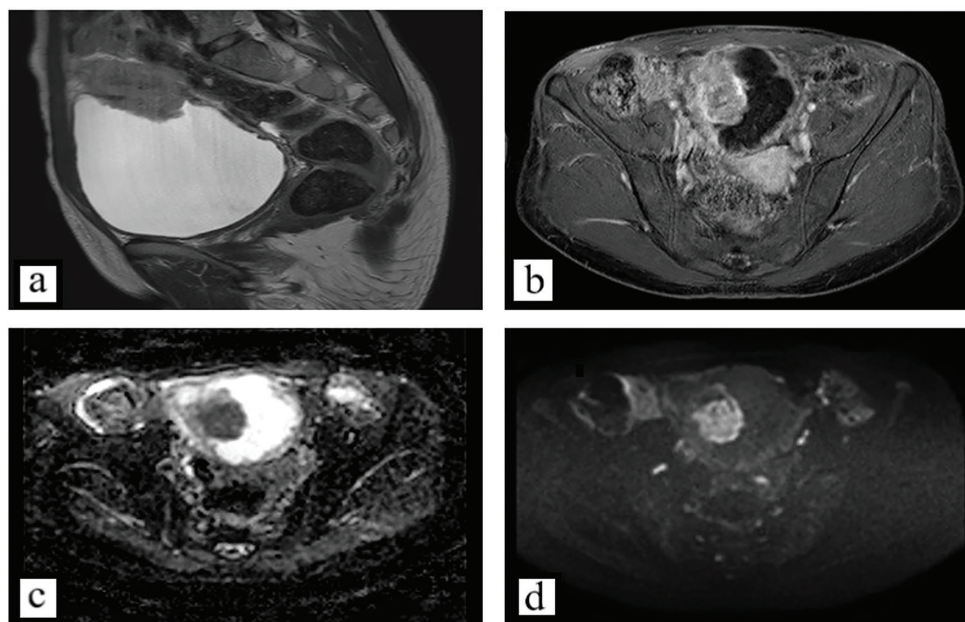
A 34-year-old woman presented with dysuria and recurrent urinary tract infections. Initial ultrasonography demonstrated a lesion in the bladder area. Subsequent magnetic resonance imaging (MRI) revealed a midline suprav vesical solid mass along the course of the urachal ligament and contiguous with the bladder dome, radiologically consistent with originating from urachal remnants. On MRI, the lesion appeared iso- to hypointense on T2-weighted sequences (Figure 1a), showed homogeneous post-gadolinium enhancement (Figure 1b), and showed restricted diffusion (Figures 1c,d). Written informed consent was obtained from the patient for the publication of her clinical information and imaging data.
